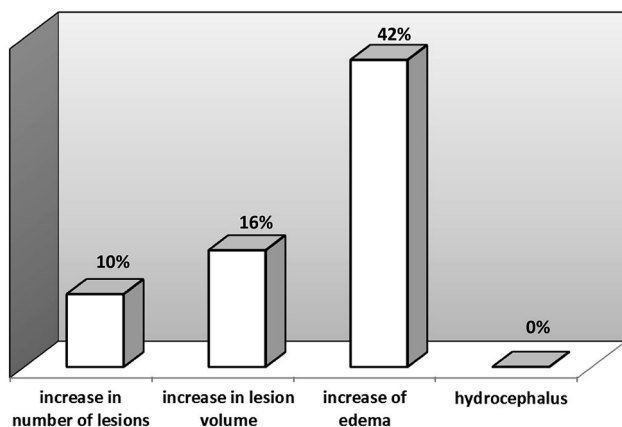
CT deterioration of the initial lesions
